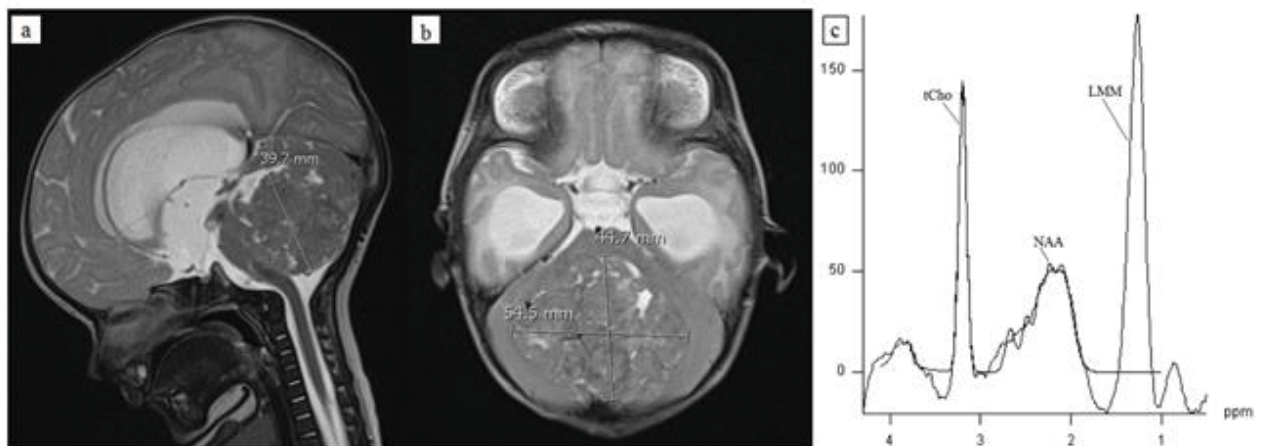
ATRT. T2-weighted sagittal and axial (a) MR images of an 8 week old baby with a metastatic posterior fossa lesion. Initial differential radiological diagnoses included ependymoma, medulloblastoma and ATRT. MRS (b) favoured ATRT with low NAA, high tCho and LMM, subsequently confirmed following open biopsy.
